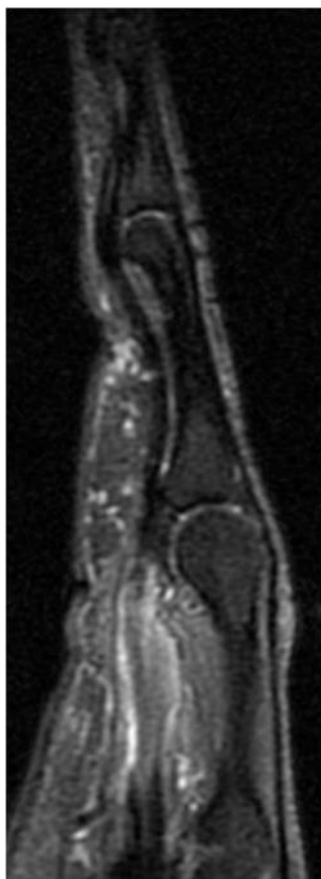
MRI demonstrating a complete rupture of the FDP tendon of the little finger.
